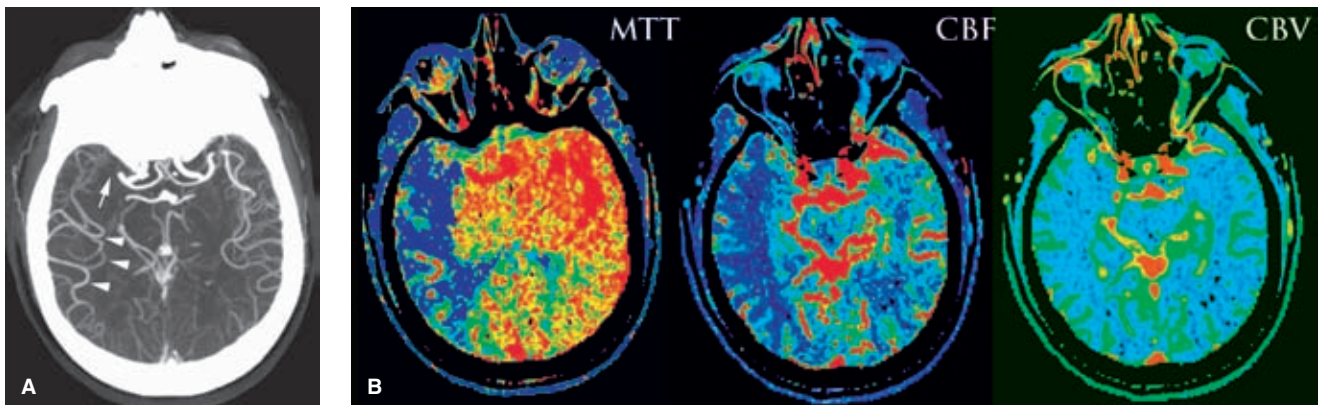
(A–F) Importance of pial–pial collateral flow I. The MIP thick slice image through the circle of Willis on the CTA is frequently one of the most helpful overall views of the study. The right M1 segment (*arrow*) is completely occluded. A defect in the distal left M1 segment is due to plane selection. The distal branches of the right middle cerebral artery territory are not just well seen, but they appear larger and more densely opacified than their left-sided equivalents. These findings are suggestive of excellent collateral flow to the right middle cerebral artery. The CTP images (B) confirm this with the MTT and CBF indicating an extensive ischemic territory in the right hemisphere with symmetry of the CBV map. (*continued*)
